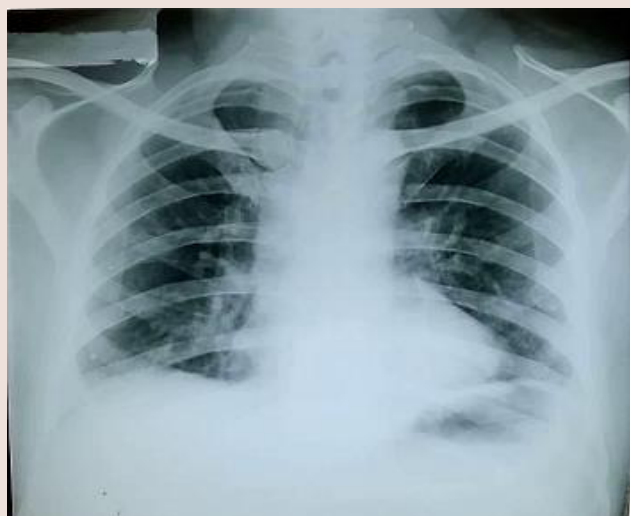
Chest X-ray taken 21 days after day 0 of COVID-19 infection and 14 days after treatment with amantadine.
